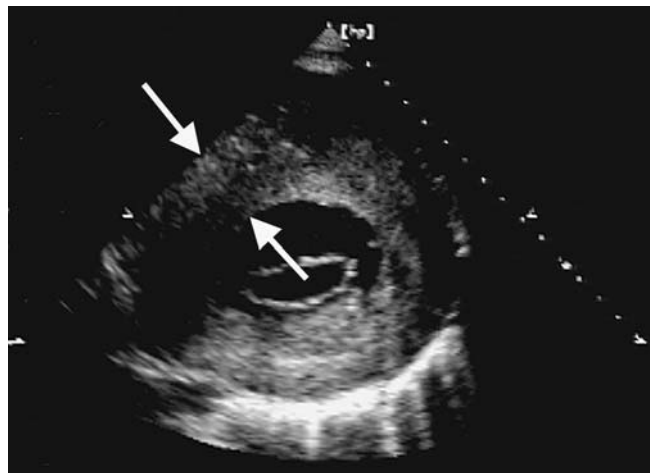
Echocardiography at age 11 years. Parasternal short axis view showing severe concentric hypertrophy of the left ventricle (arrows)
